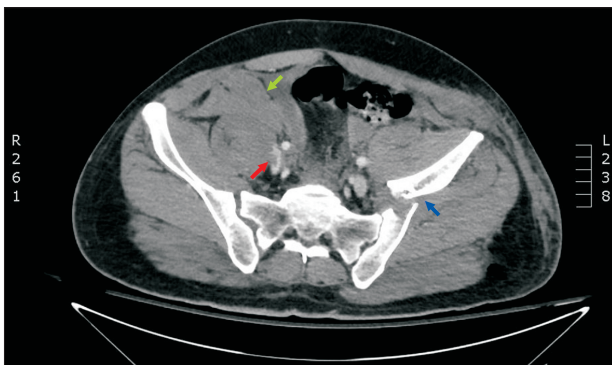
Computed tomography axial image showed thrombosis of the right common iliac vein (red arrow), hematoma in the right pelvic fossa (green arrow), and left pelvic bone fracture (blue arrow).
